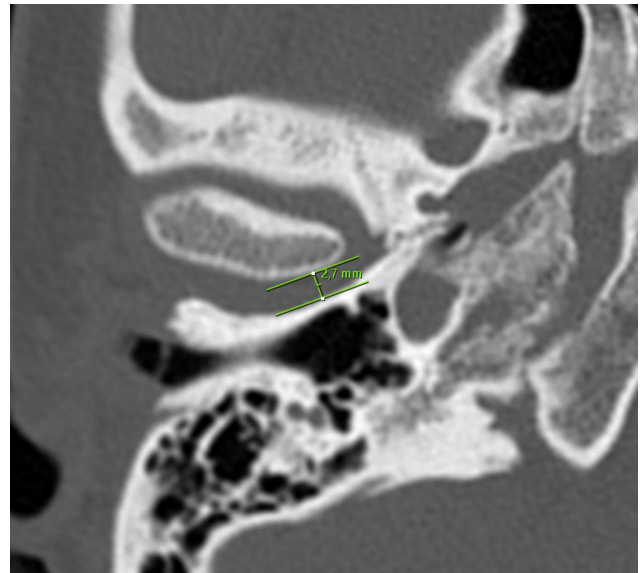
Temporal CT image of a 24-year-old woman (Right JSNTT).
